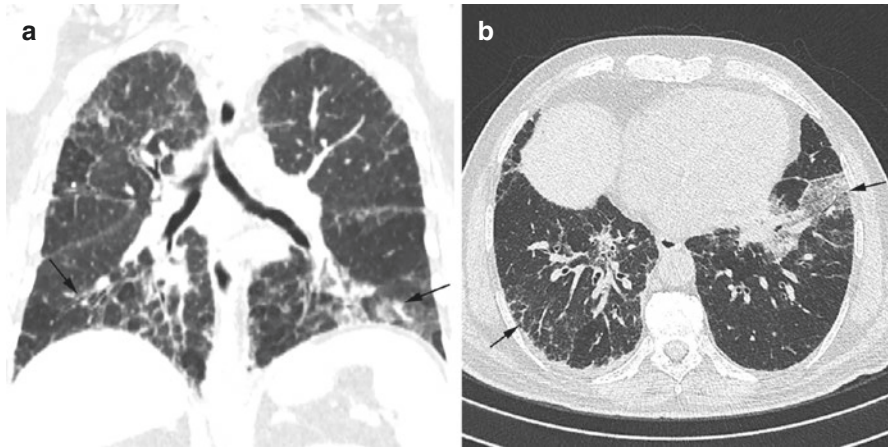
Bleomycin toxicity in a patient with non-Hodgkin's lymphoma. (a) coronal, and (b) axial, lung window, CT images show reticulations and ground glass opacity in bilateral lungs, with basal predominance, consistent with bleomycin toxicity
